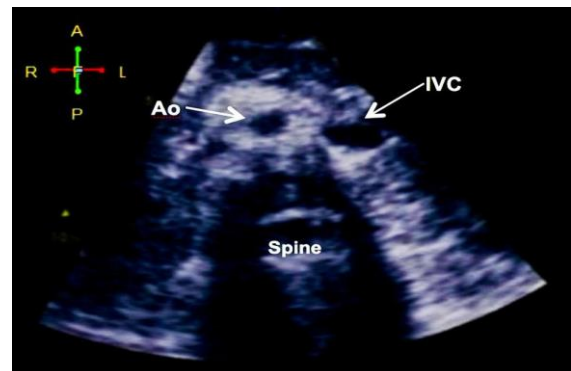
Situs Inversus as visualized in ultrasound abdomen. (A) Subcostal view showing the aorta (Ao) and the inferior vena cava (IVC) in relation to the spine: the aorta (more pulsatile) is at the right while the IVC (collapsible) is on the left (visceral situs inversus).
